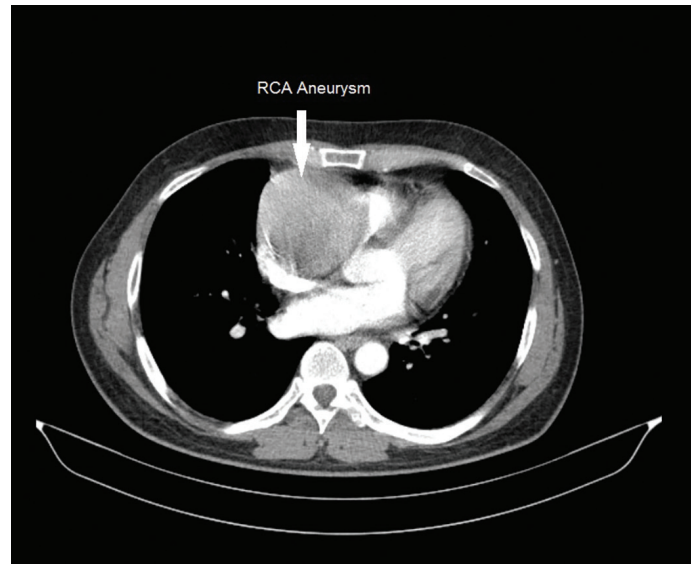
Computed tomography showed a cystic mass with a maximum diameter of 9 cm, which was adjacent to the aortic root and compressing over the superior vena cava, right atrium, and right ventricle.
